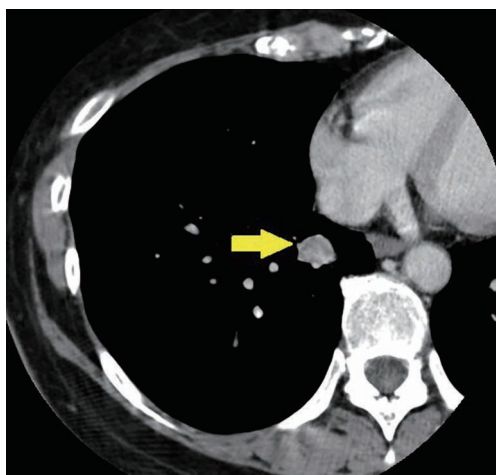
Chest enhanced CT showing a tumor in the right lower lobe of the lung (arrow). The tumor showed enhancement and measured 2.6 cm in diameter. CT, computed tomography.
